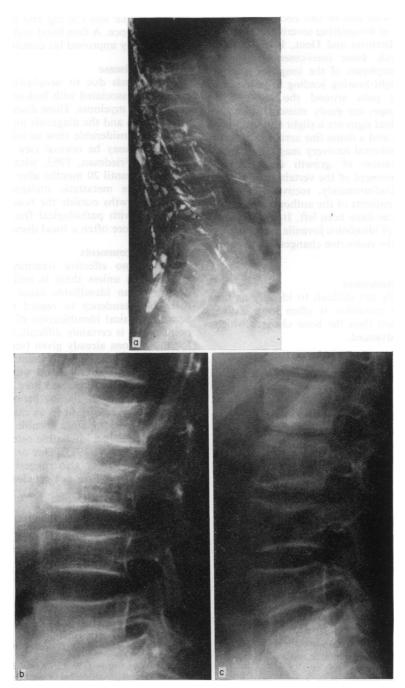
Osteoporosis associated with dietary calcium deficiency. Serial X-ray of the spine ((a) May 1958; (b) August 1961; and (c) April 1964) showing severe osteoporosis with vertebral collapse and gradual improvement.
